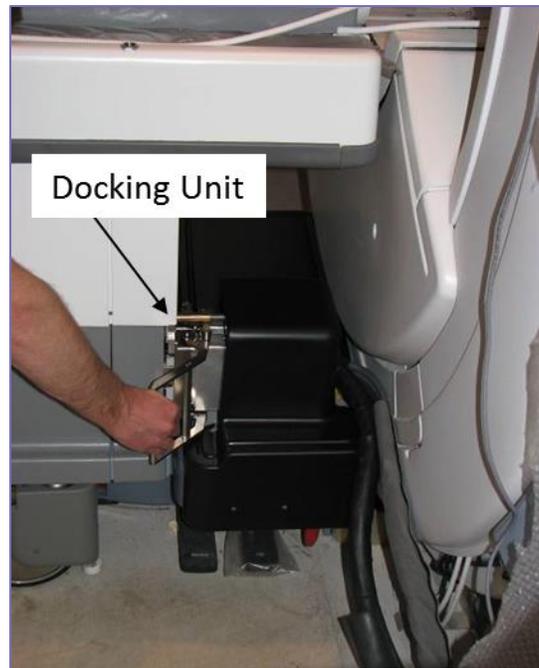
Exablate 2100V1 Connection of the Table To the MRI
